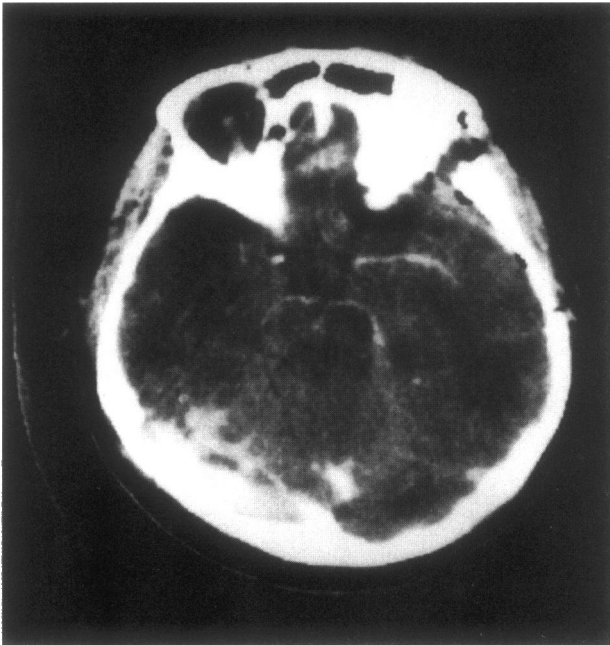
Postoperative control CT demonstrates total removal of the lesion.
